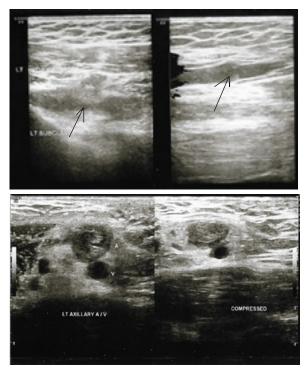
Venous ultrasound that show (from left to right) A. Thrombus on proximal basilic and subclavian vein B. Thrombus on left axillary vein C. Left axillar vein before compression D. Left axillar vein that uncompressible due to thrombus.
